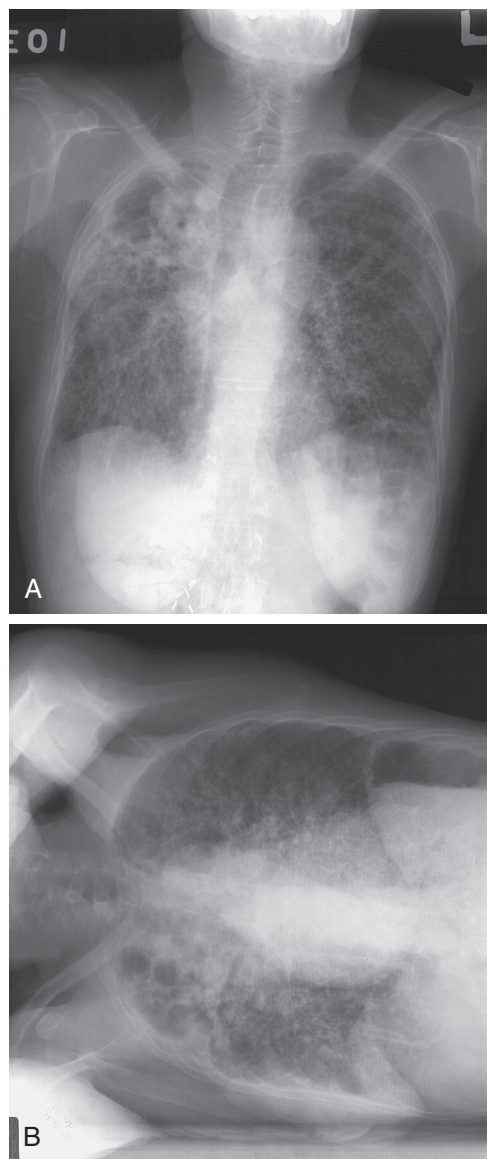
■ Posteroanterior (A) and decubitus (B) chest radiographs demonstrating an aspergilloma within a right upper lobe cavity. The fungus ball “moves” with change in patient position.
